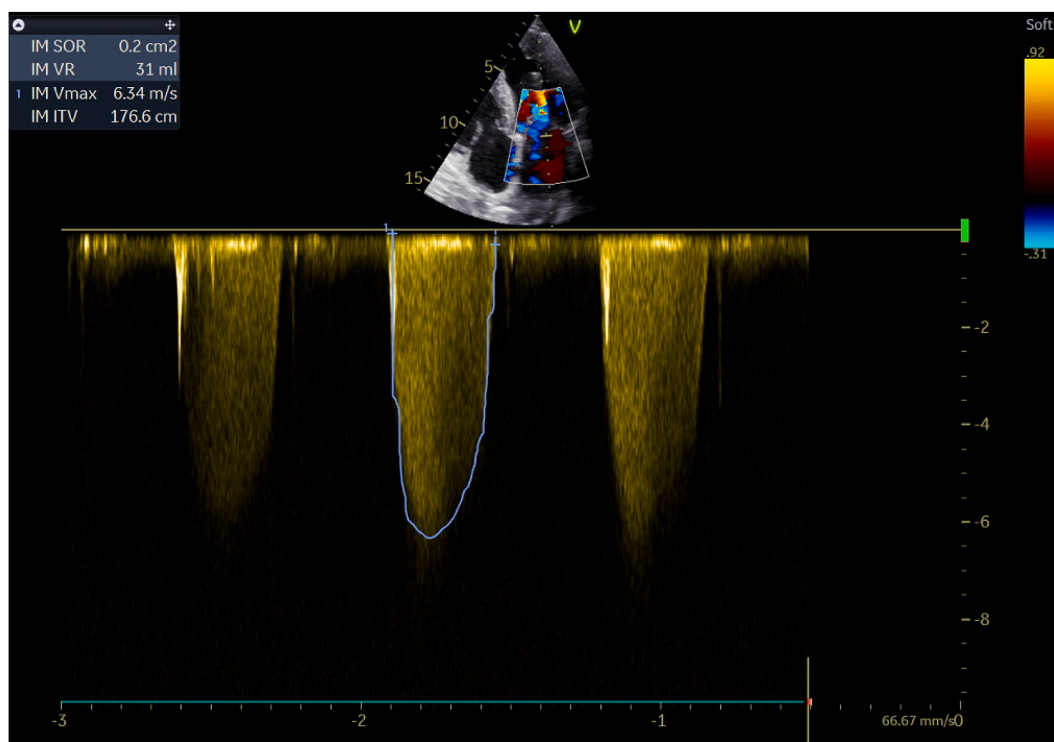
Echocardiography: continuous Doppler on the mitral valve showing a Moderate mitral regurgitation.
